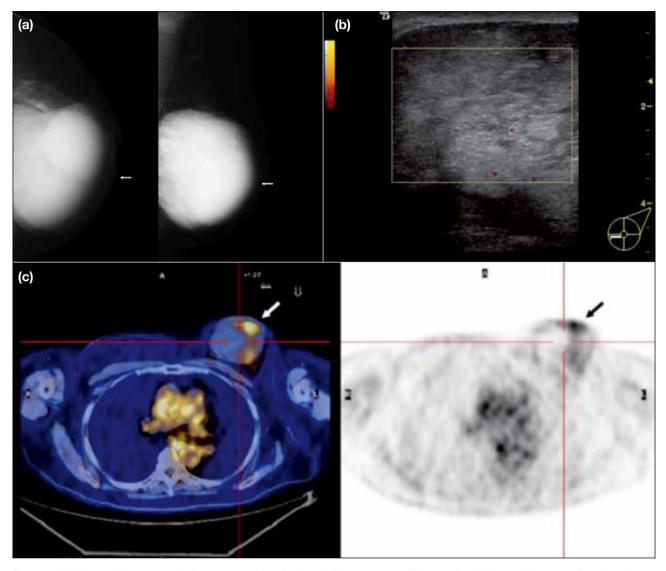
A 60-year-old woman with late presentation of a huge left breast mass. Ultrasound-guided core biopsy confirmed mucinous carcinoma. The patient received palliative radiation therapy and chemotherapy (a) Mammograms with craniocaudal (left) and mediolateraloblique (right) views showed a large (>10-cm) round, high-density mass with circumscribed margins in the left breast, with an enlarged axillary lymph node. (b) Ultrasonogram showed a large hypoechoic solid mass with circumscribed margins and mild internal vascularity. (c) Positron-emission tomography–computed tomography scan showed hypermetabolic areas within this tumour, with lung secondaries (not shown).
